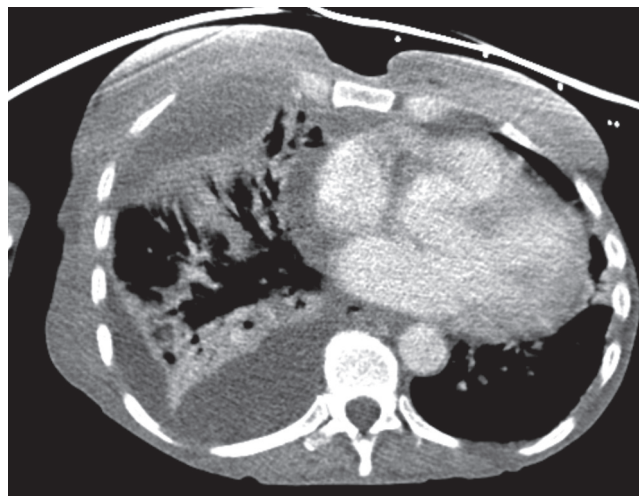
■ CT scan showing separate basilar loculations of fluid, suggesting the need for intraoperative drainage.
